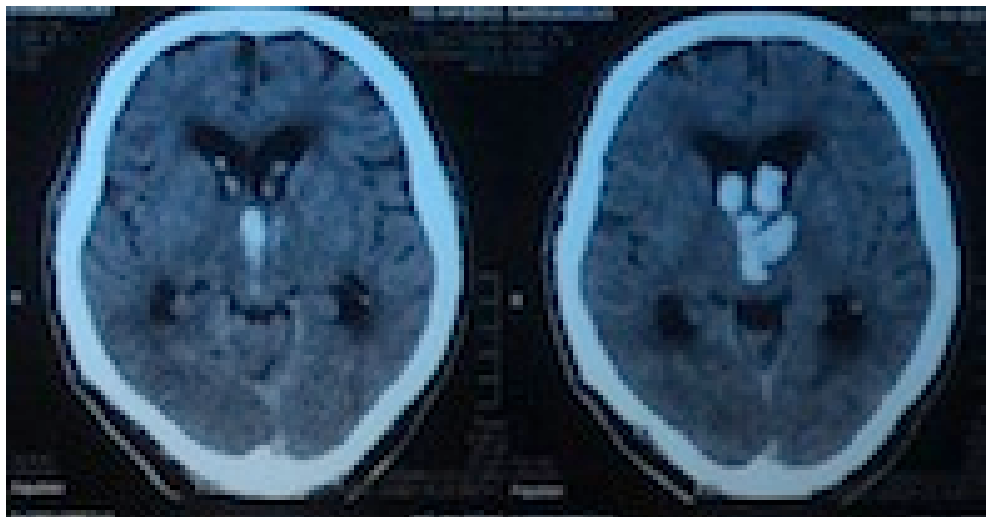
Axial view of plain CT brain showing left thalamic haemorrhage with intraventricular extension with hydrocephalus. (Ishii *et al.*, 2008)
